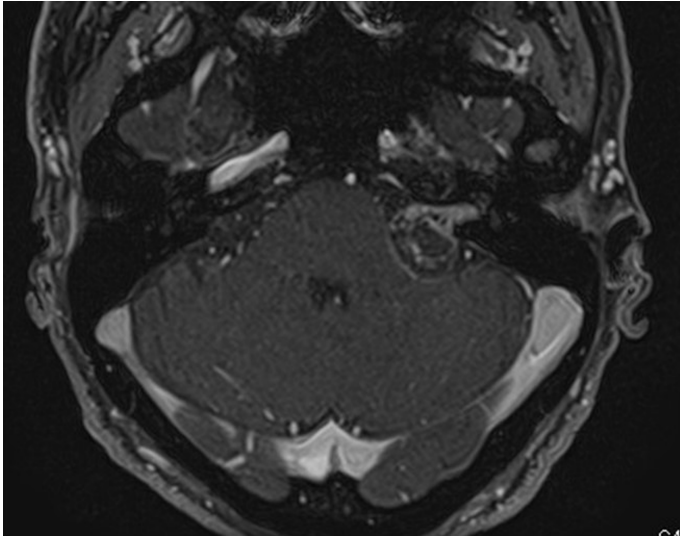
Preoperative magnetic resonance image. A 16-mm-sized vestibular schwannoma with marked cystic degeneration is observed in the left cerebellopontine angle. The tumor obscures the internal ear canal and contacts and presses the brainstem.
